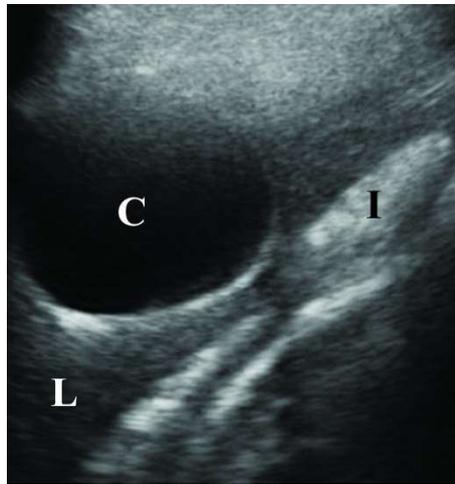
Abdominal ultrasound (L - liver; C – cyst; I – intestine)
